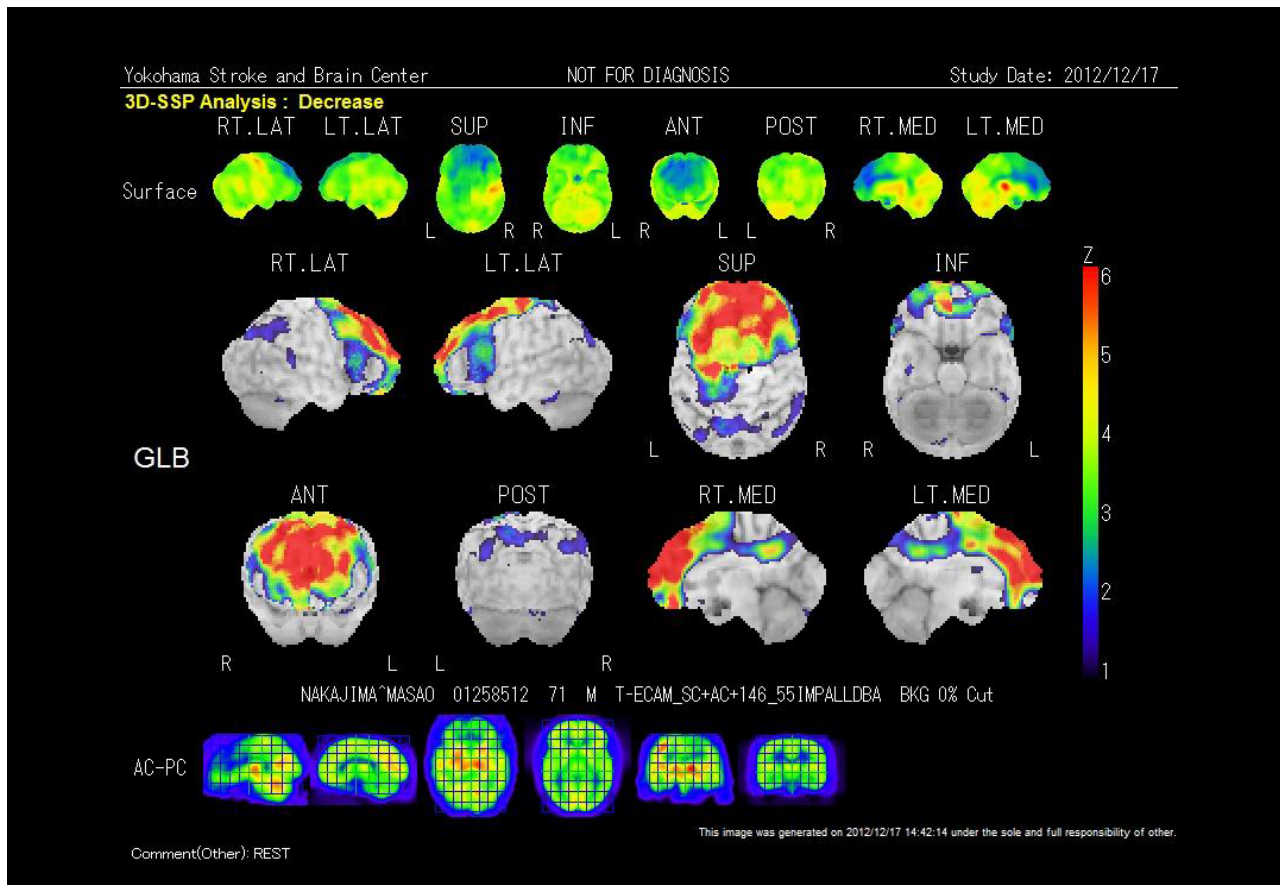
SPECT perfusion images.
